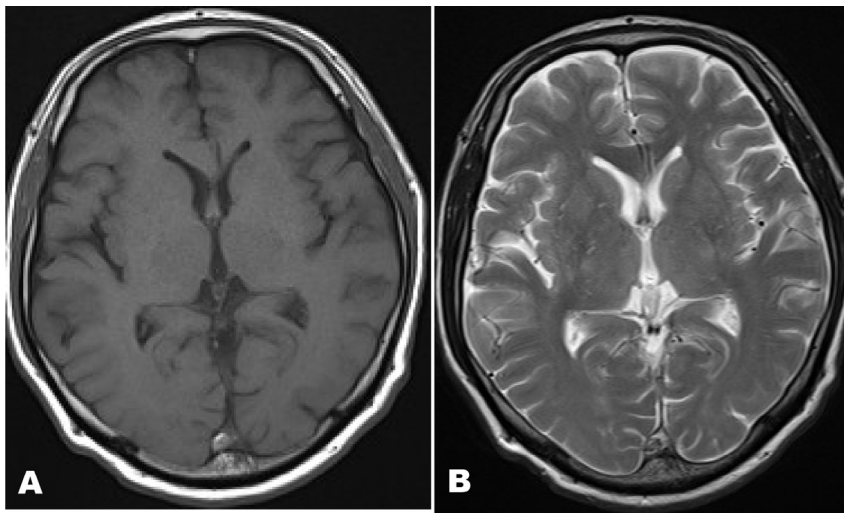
T1-weighted magnetic resonance image (A) and T2-weighted image (B). These images indicated signal intensity alternation in the posterior aspect of the superior sagittal sinus (A and B).
